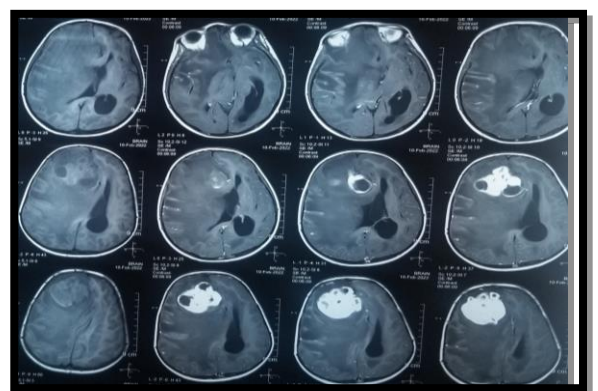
Brain MRI T1 (axial cuts) showing a mass within the right frontal lobe with surrounding extensive vasogenic edema and midline shift
